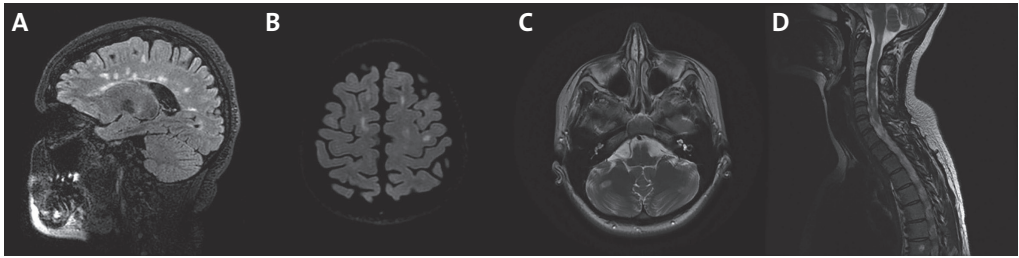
Typical MS lesions on brain MRI: A periventricular, B juxtacortical, C infratentorial, D spinal cord
